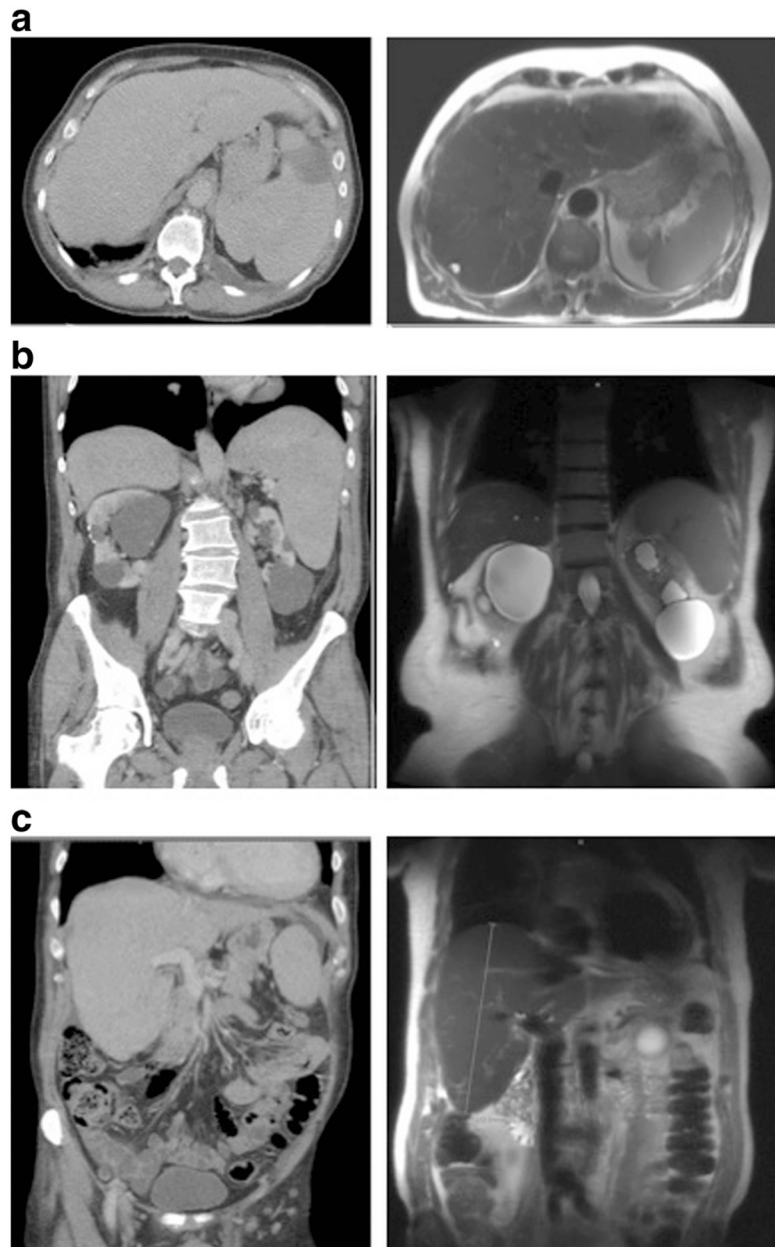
Pre- and post-ruxolitinib therapy contrast-enhanced CT scans. a Axial view pre- and post-treatment. b Coronal view splenomegaly preand post-treatment. c Coronal view hepatomegaly pre- and post-treatment
